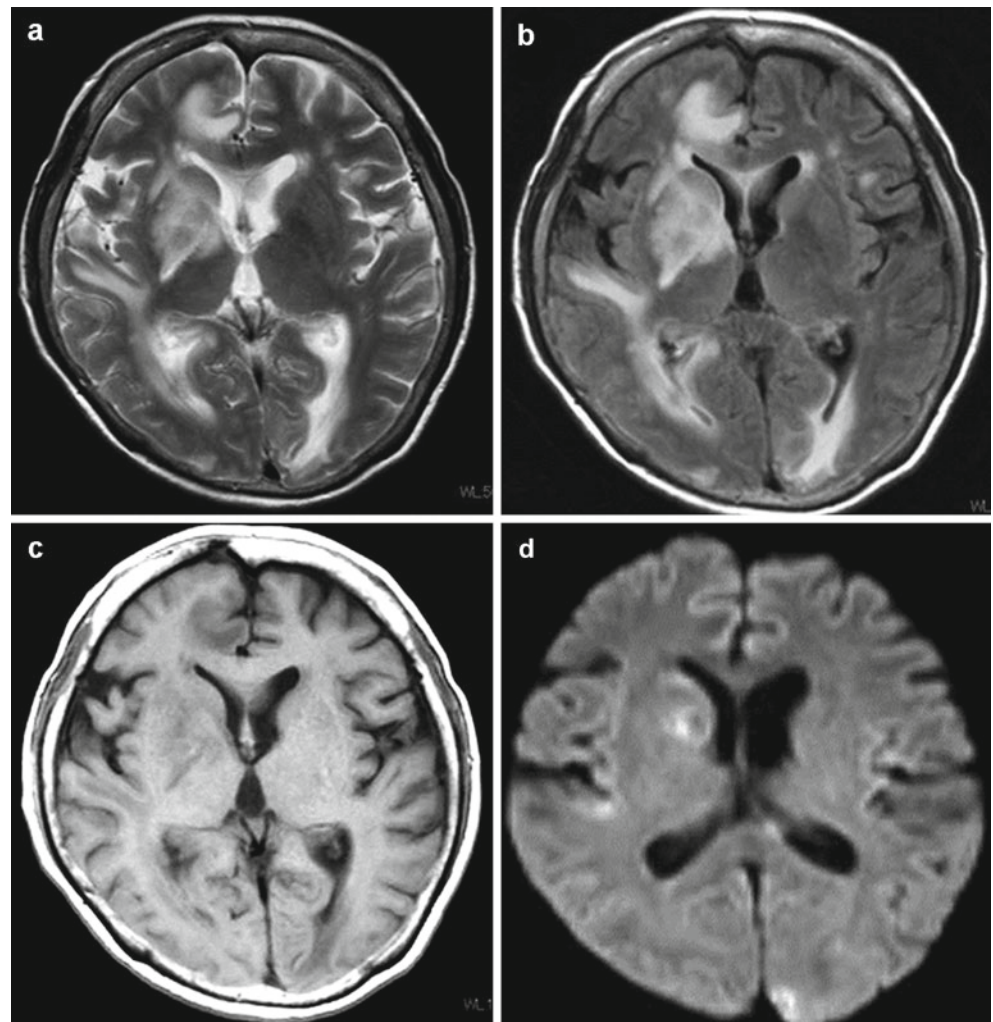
Posttransplant lymphoproliferative disorder after renal transplantation. Note the multiple, mainly periventricular lesions with prominent perifocal edema and heterogeneous signal intensity on T2-weighted (a) and fluid-attenuated inversion recovery (FLAIR) (b) images. Almost isointense signal intensity is seen on T1-weighted images (c). There is a high intensity signal on diffusion-weighted imaging (d)
